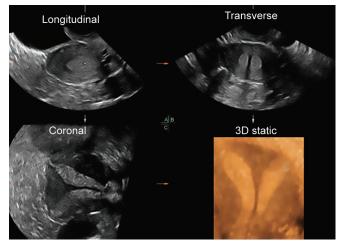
Three-dimensional ultrasound scan of the same patient
